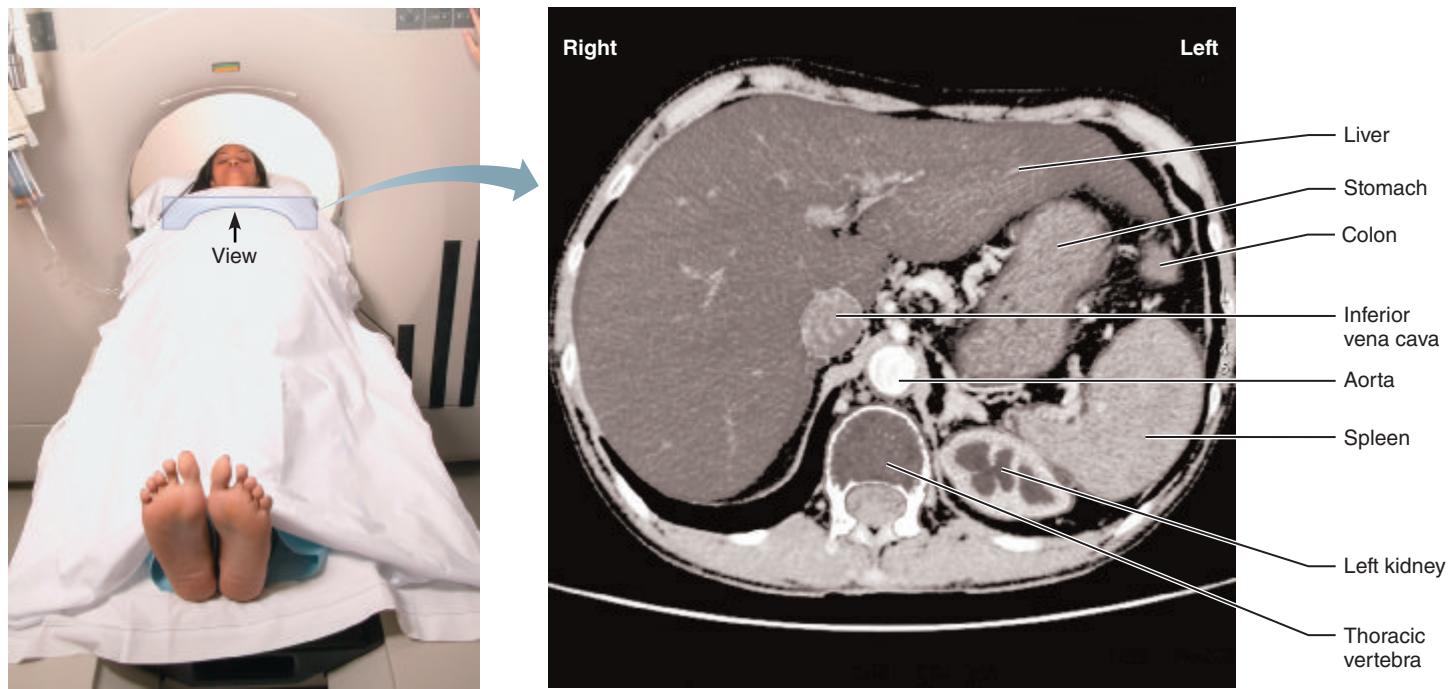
Computed tomography (CT). CT scan through the upper abdomen.
